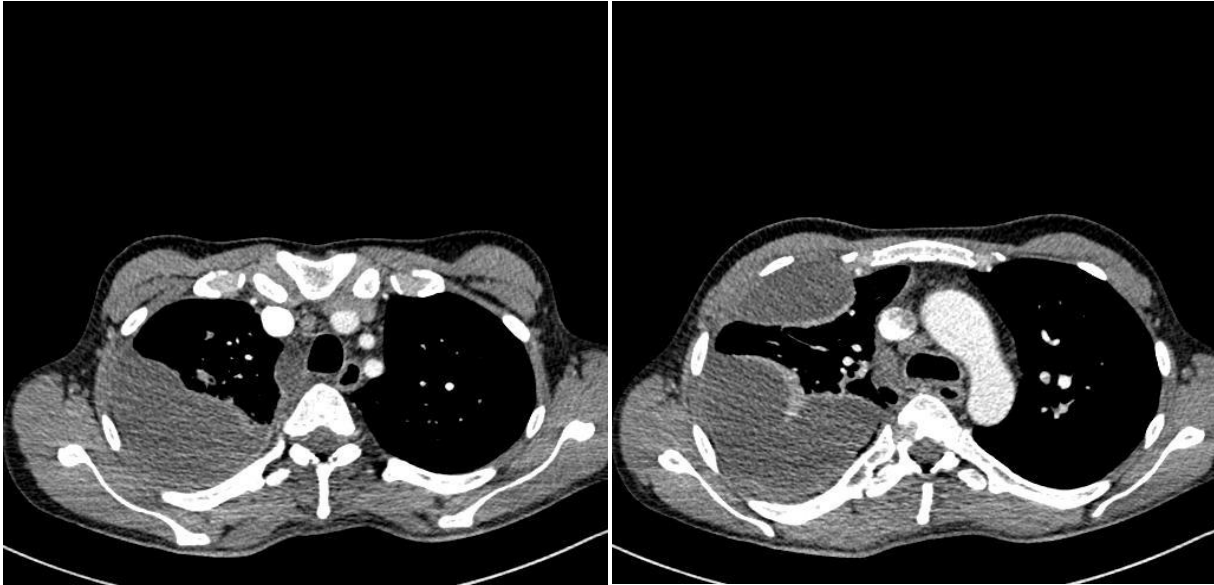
Thoracic CT scan: Atelectasis of the middle lobe, subsegmental atelectasis of the lower lobe due to fluid accumulation in the right pleural space.
